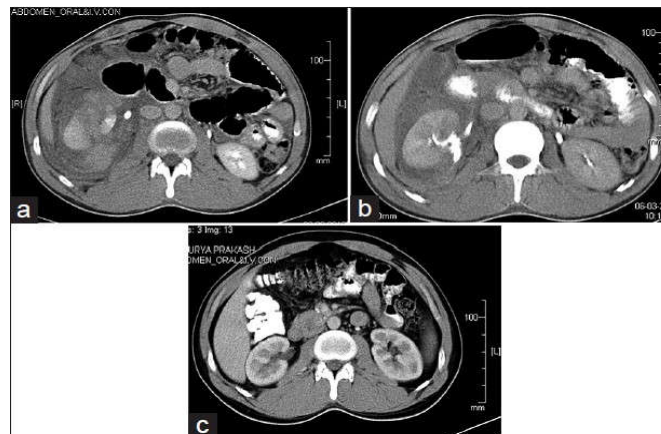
Axial section of CECT pictures showing (a) initial CT showing Grade IV renal injury, (b) contrast extravasation after 48 hours, and (c) completely resolved hematoma at 1-year follow up
